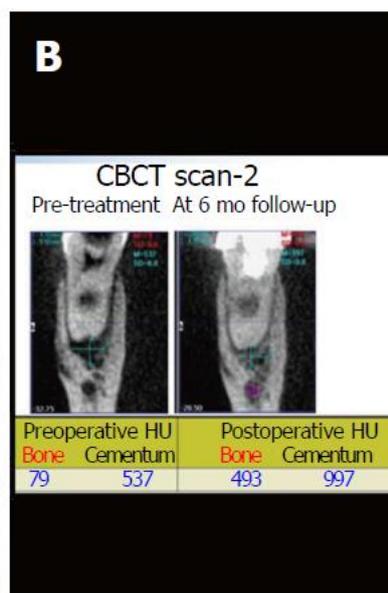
Figure Cone beam computed tomography. A: A cone beam computed tomography scan gives a three-dimensional view of the area of interest. In this case, the periapical lesion is being evaluated; B: The image gives values in Hounsfield unit of cementum and alveolar bone density to measure posttreatment healing. CBCT: Cone beam computed tomography.^[21]
